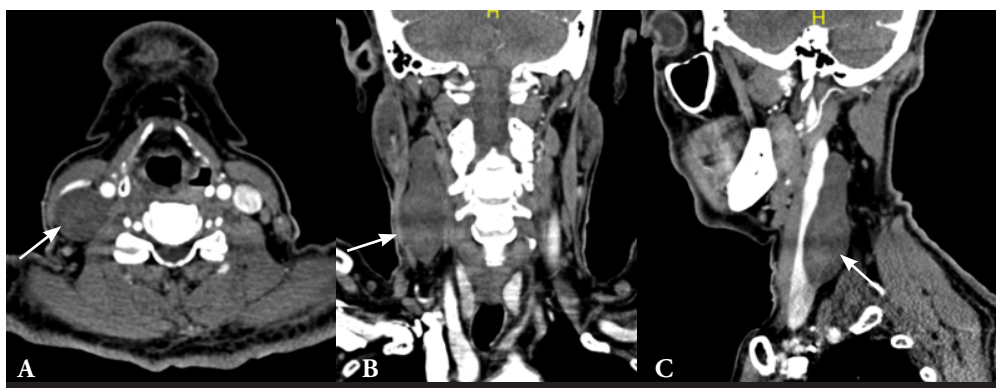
CT scan images in axial (a), coronal (b) and sagittal (c) planes showing a well-defined, mildly-enhanced mass in the right posterior carotid space (white arrow).
